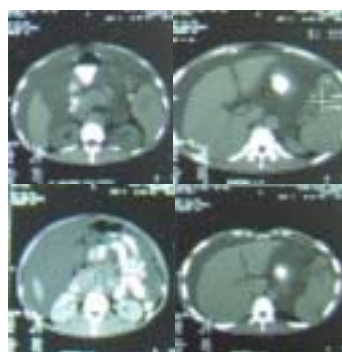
Abdominal CT scan before admission showed ascites, paraaorta lymph nodes enlargement, and splenomegaly with multiple hypodens lesion
